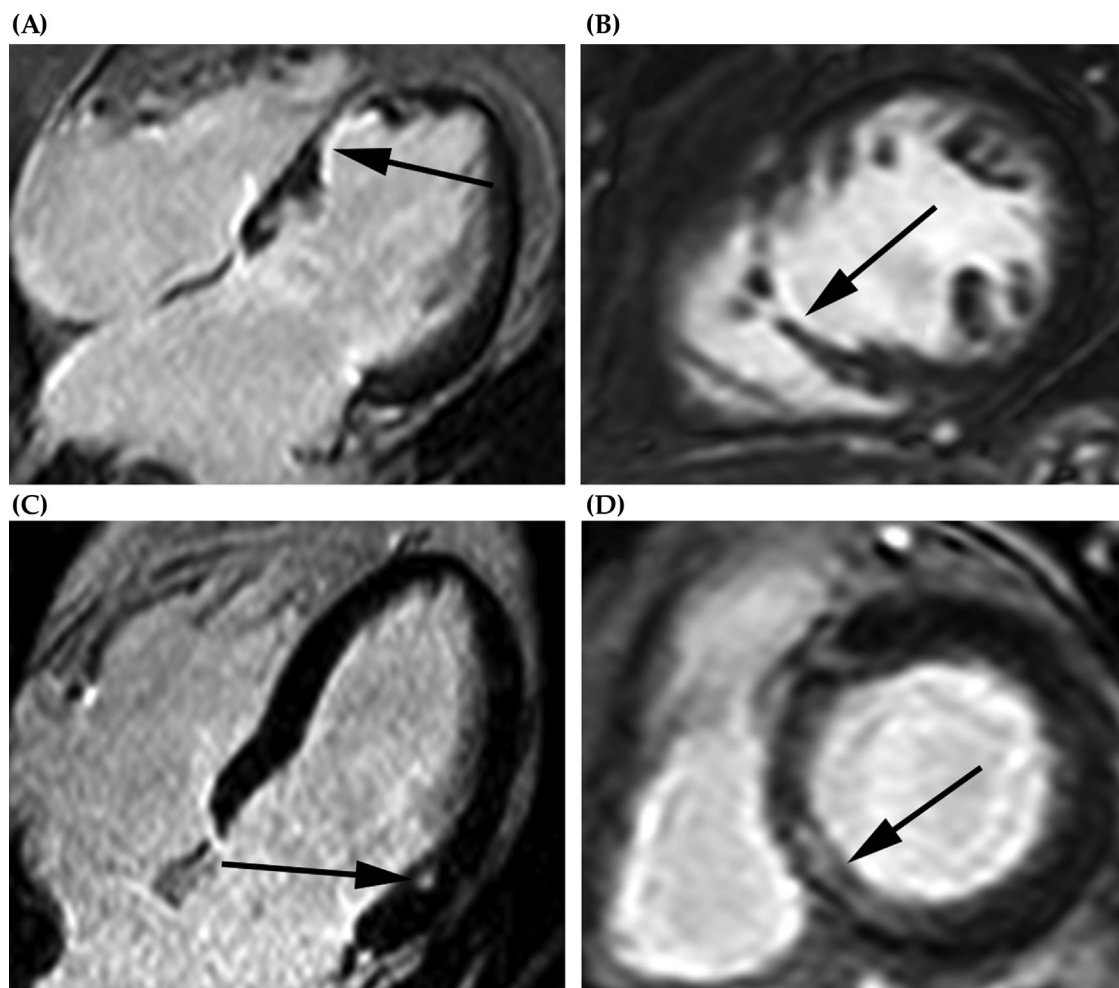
Cardiac MRI of two representative GPA patients and their LGE patterns. Subendocardial late gadolinium enhancement (LGE) with reduced wall thickness in a 64-year old GPA patient, demonstrated in 4-chamber (A) and short-axis plane (B). Small basal midmyocardial LGE in a 60-year old GPA patient, demonstrated in 4-chamber (C) and short-axis plane (D). *Adapted from the personal collection of the authors.*
